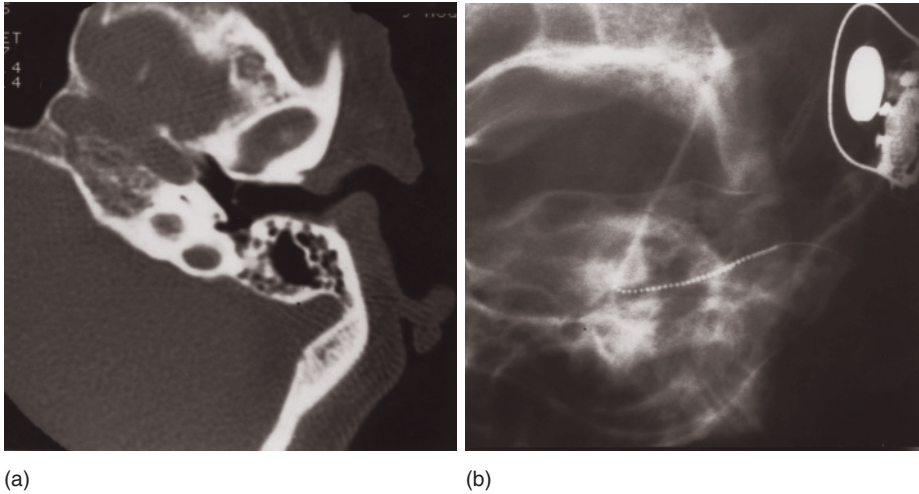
(a) CT scan showing advanced obliteration of the cochlear lumen by new bone. (b) Partial electrode insertion in the obliterated cochlea.
